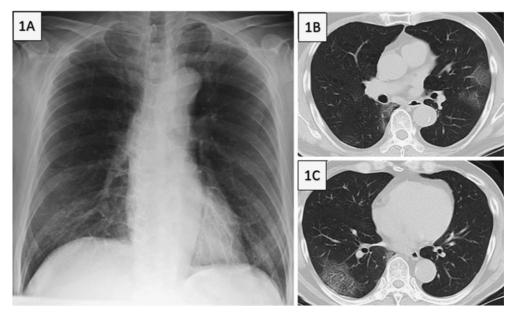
Chest X-ray and CT findings
